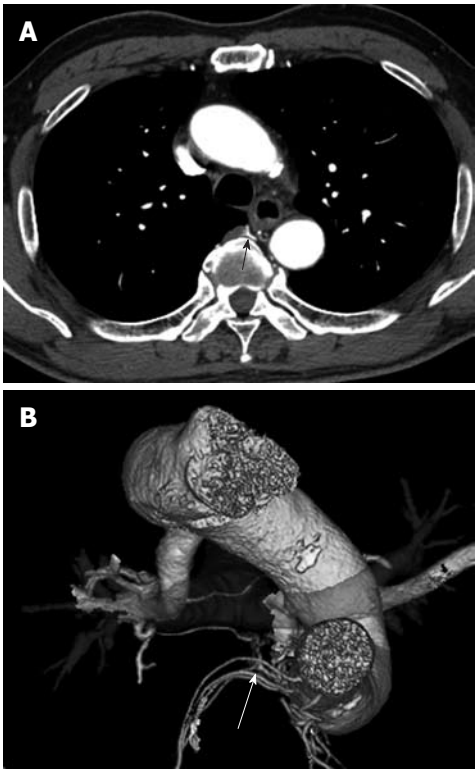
Right bronchial artery branches with an intercostal artery (arrow) at the approximate ventral center of the thoracic vertebra, shown on an axial computed tomography scan with mediastinal soft-tissue window settings (A) and on a thin-section maximum intensity projection image of a 3D volumetric reformatted image (B).
